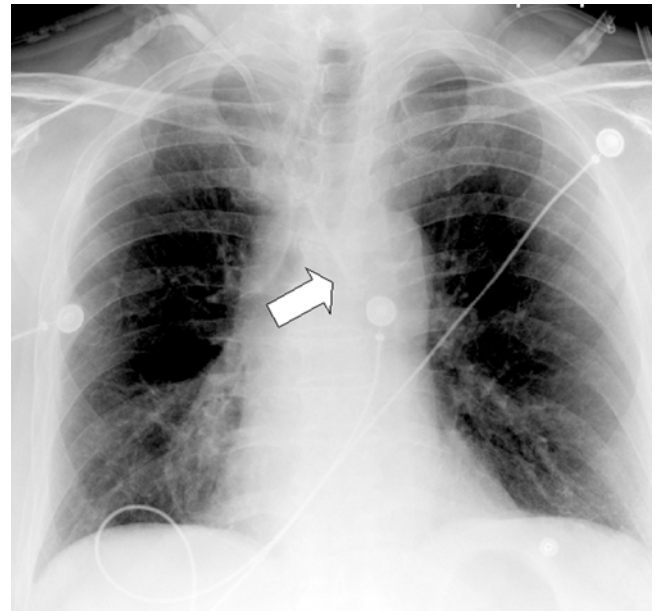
Chest x-ray after placement of jugular line. Arrow demonstrates catheter tip crossing midline with respect to the trachea
